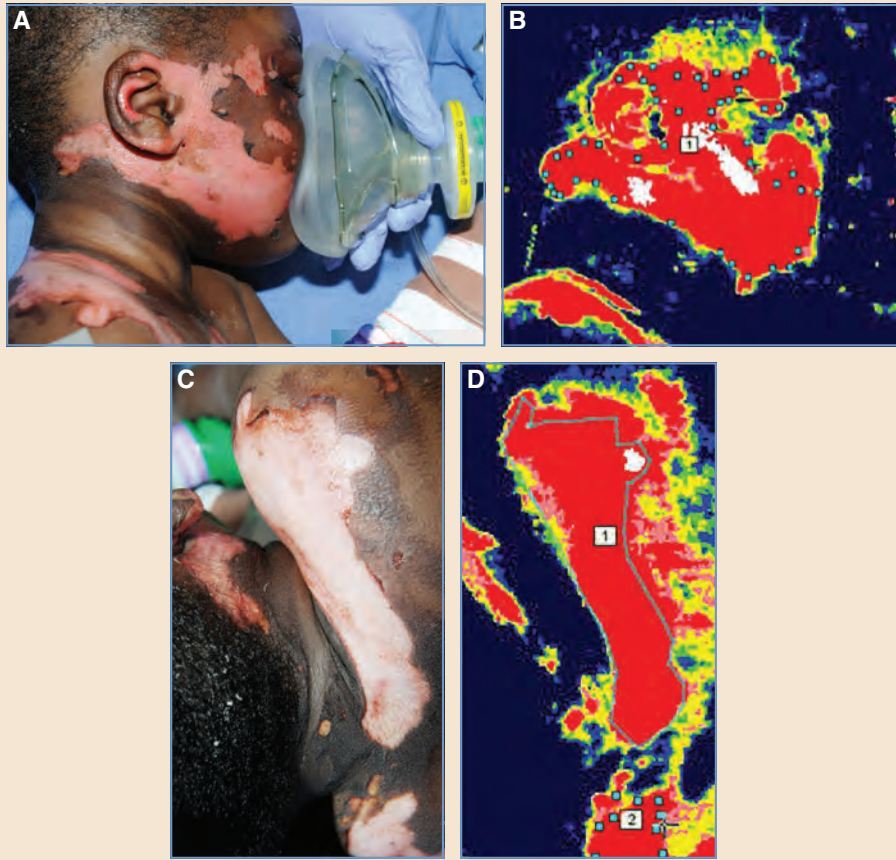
A, This patient has a full facial scald burn and is shown 24 hours after the injury, during debridement and application of a dressing. B, A laser Doppler image indicates a high likelihood of healing to all areas, as evidenced by the *red area*. C, Second-degree burns to the shoulder area. D, A laser Doppler image of the shoulder area.
